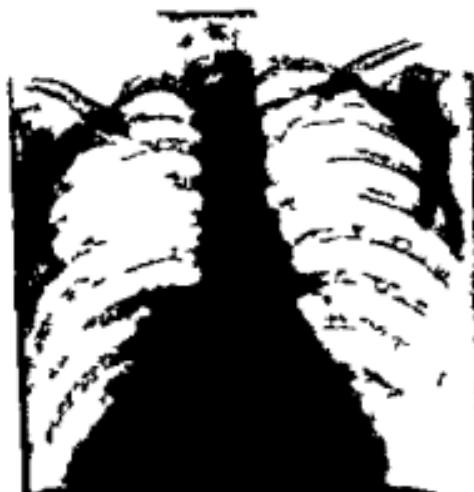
Case III. Beds de roentgenogram made eleven days after pel c operation. Note clouding at right base representing residual pulmonary infection. Also note that the diaphragm is in about its normal position; more of the lung field can be visualized and hence there is less confusion about the diagnosis.
